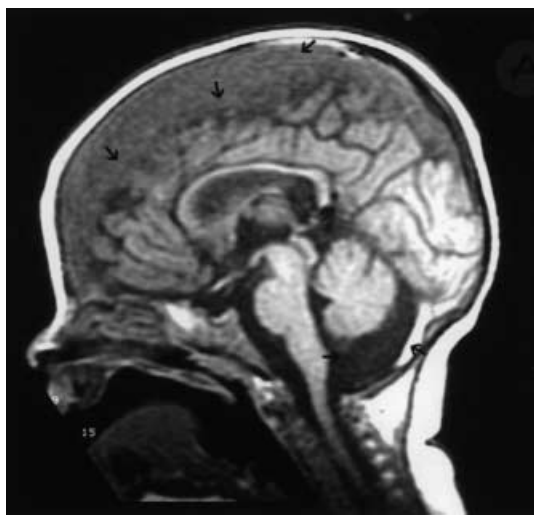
MRI scan showing subacute subdural haemorrhage layering under the tentorium (*bottom arrow on the right*), acute on chronic parafalcine subdural (*top arrows*) and subarachnoid fluid in an enlarged cisterna magna (*bottom arrow on the left*)
